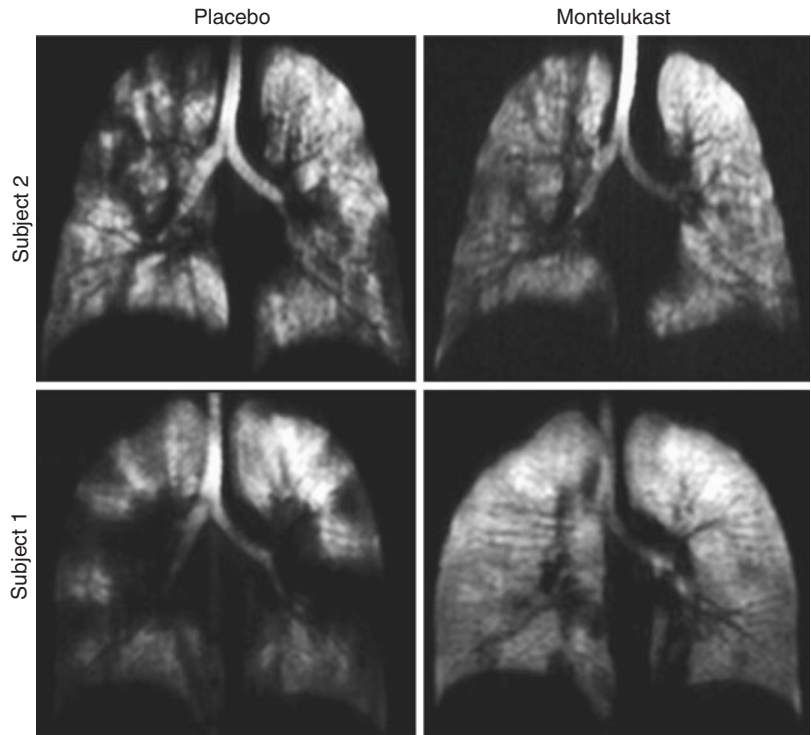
Treatment response to montelukast during exercise-induced bronchoconstriction in two asthma subjects. Improvements in ventilation as shown by hyperpolarized ³He contrast-enhanced MRI can be seen in two representative asthma subjects (Subject 1:21 y/o female; Subject 2:28 y/o male)
